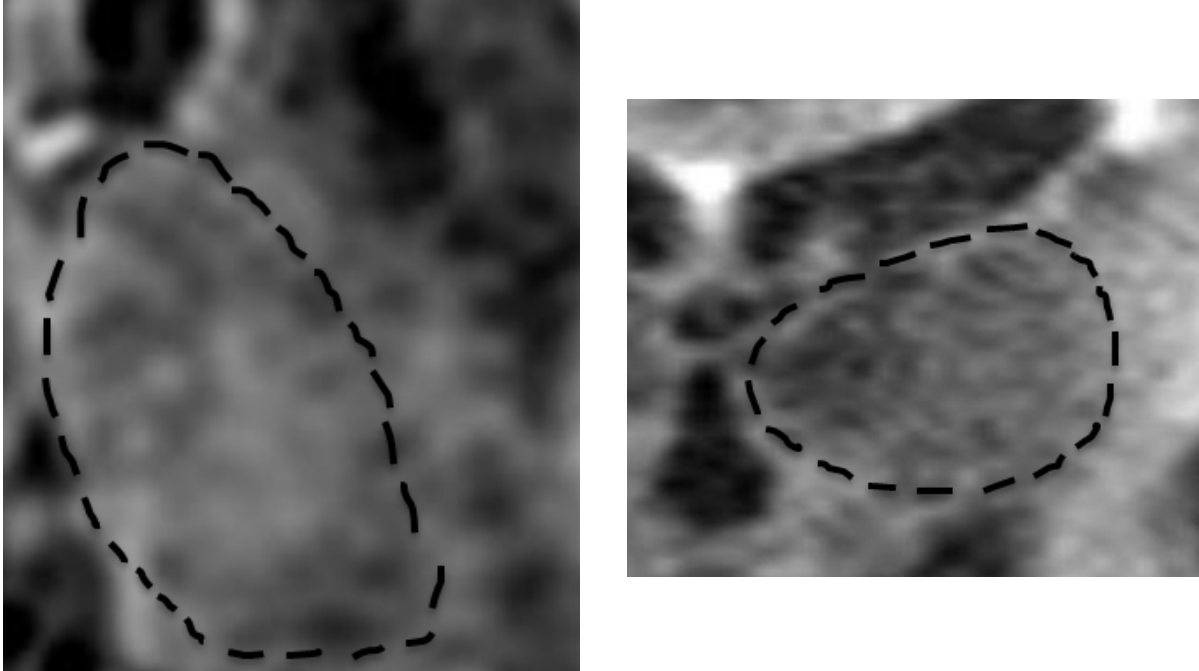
Thalamic tracing for one patient. MR images of the thalamus. The thalamic border is indicated by the dashed lines. Axial and coronal views are displayed.
